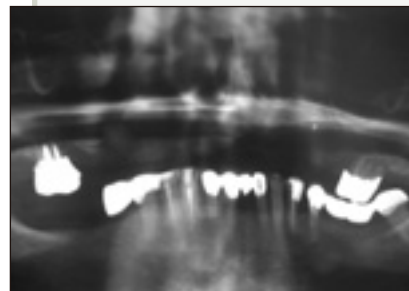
Panorex radiograph shows minimal maxillary alveolar bone with pneumatization of the antra and periodontally hopeless teeth 17 and 27. Note the natural mandibular dentition.
